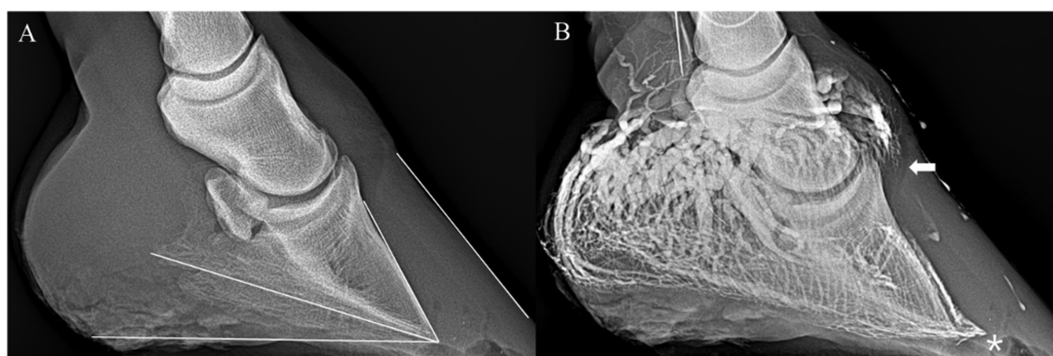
A. Lateromedial radiograph of the patient diagnosed with PPID. The dorsal surface of the hoof, dorsal surface of the distal phalanx, solar surface of the distal phalanx, and the ground surface are emphasized by white lines. There is evidence of dorsal capsular and phalangeal rotation of the distal phalanx, an increased angle between the solar surface of the distal phalanx and the ground surface, and decreased sole depth. B. Venogram of the laminitic foot of the patient diagnosed with PPID. The apex of the distal phalanx descends distally to the circumflex vessels (asterisk), and the coronary plexus is distorted with reduced contrast and evidence of reduced blood supply (arrow).
